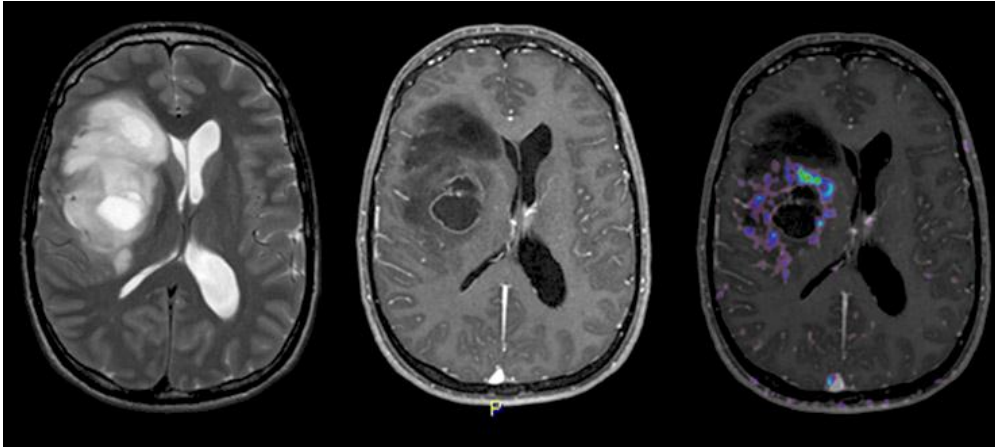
Magnetic resonance imaging (MRI) of right fronto-temporal glioblastoma
